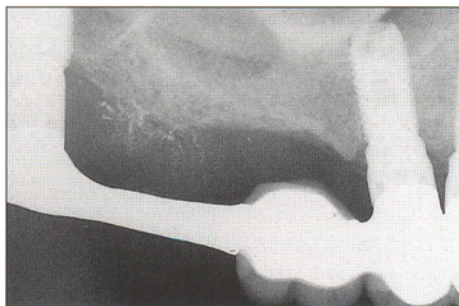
Seven-year postloading radiograph.
